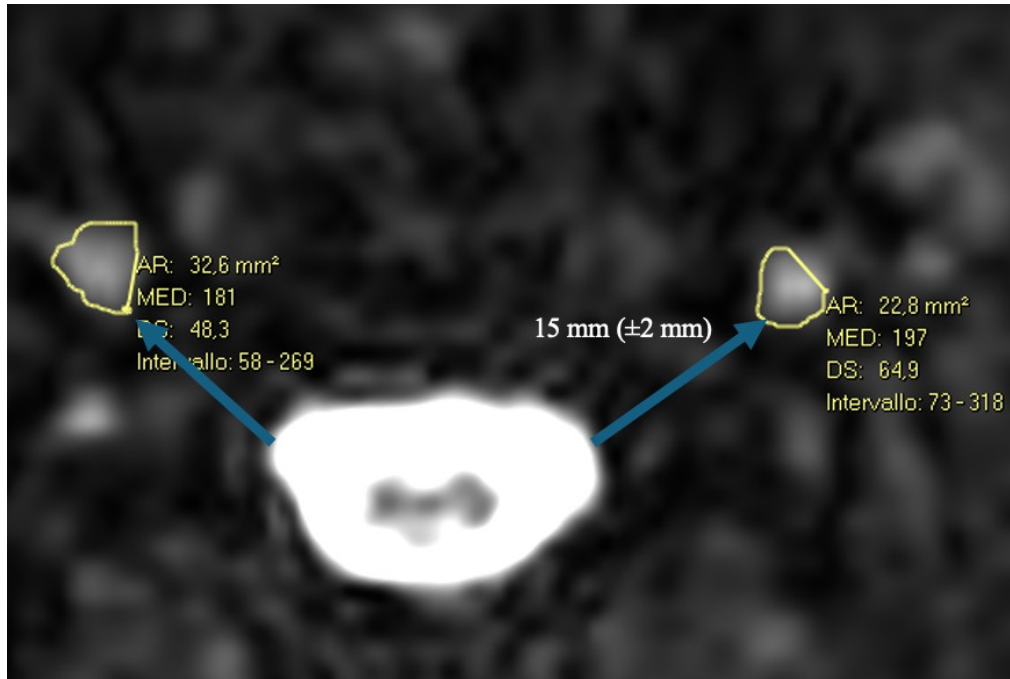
Axial image from MRI in 3D Cube Nerves, with quantitative measurements of the nerve roots to analyze in CSA and T2-weighted intensity signal (AR and MED). In this case, the observed measurements is C5 roots of a patient with PTS: right pathologic root compared with the left not pathologic.
